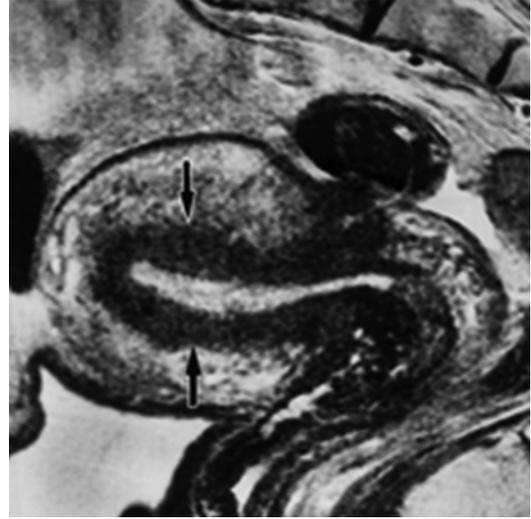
T2 MRI of uterus with diffuse adenomyosis (black arrows)
